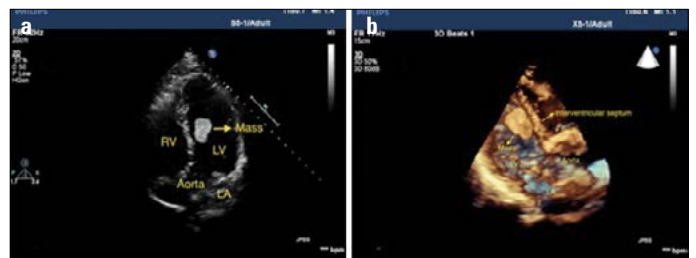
(a) Apical five-chamber view showing a homogeneously echodense, round, mobile mass within the left ventricular cavity. (b) Real-time three-dimensional transthoracic echocardiography showing a left ventricular mass and interventricular septum.
